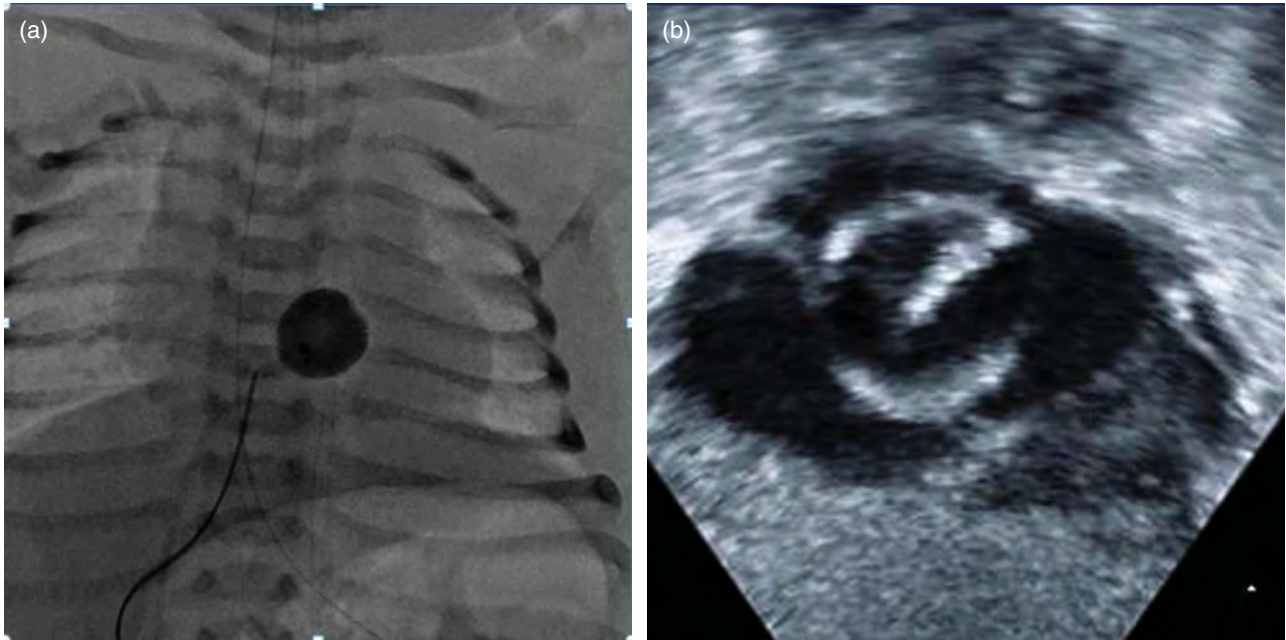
(a) Fluoroscopic image of a balloon inflated in the left atrium, ready to be pulled across the atrial septum for a balloon atrial septostomy. (b) Echocardiographic image of a balloon filling most of the left atrium prior to balloon atrial septostomy. Note the tenting of the atrial septum towards the right atrium, with tension placed on the balloon catheter.
